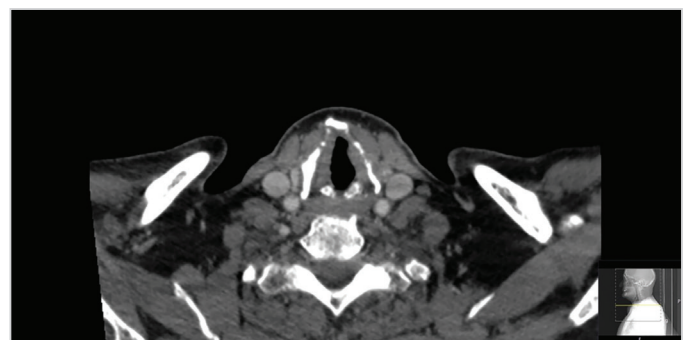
Computed tomography of the neck with contrast after ADT (axial image) showing almost complete response to therapy
